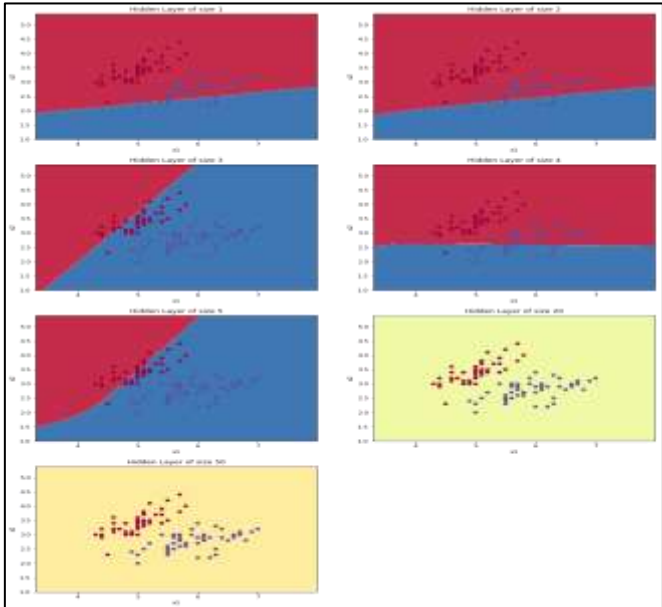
Exection Process—output—Decision Boundaries of Different Classifiers for Normal vs. Abnormal Fetal MRI Classification.
